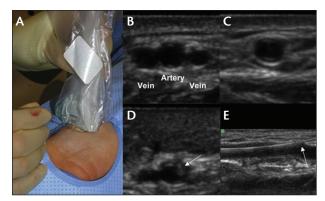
Technique of ultrasound-guided radial access. Axial position of draped ultrasound probe over the right radial artery. The needle is inserted just below the center of the probe when the artery is in the center of the image plane (A). Visualization of radial artery and veins (B). Compression causes closure of radial veins and reveals pulsatility of artery (C). Visualization of the needle tip (arrow) compressing and puncturing the artery (D). Confirmation of wire position (arrow) in the radial artery in longitudinal plane (E). Reprinted from JACC Cardiovasc Interv, 8, Seto AH, Roberts JS, Abu-Fadel MS, et al, Real-time ultrasound guidance facilitates transradial access: RAUST (Radial Artery Access With Ultrasound Trial), 283–291, 2015, with permission from Elsevier.
